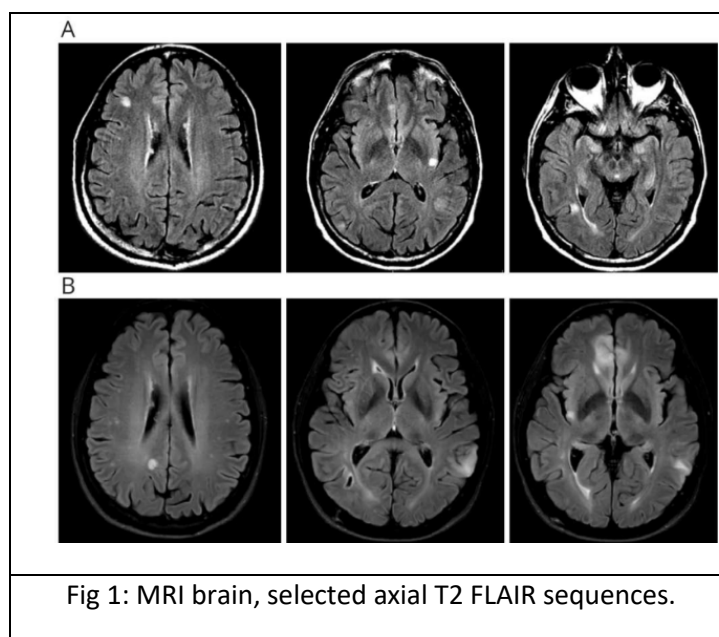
MRI brain, selected axial T2 FLAIR sequences.
